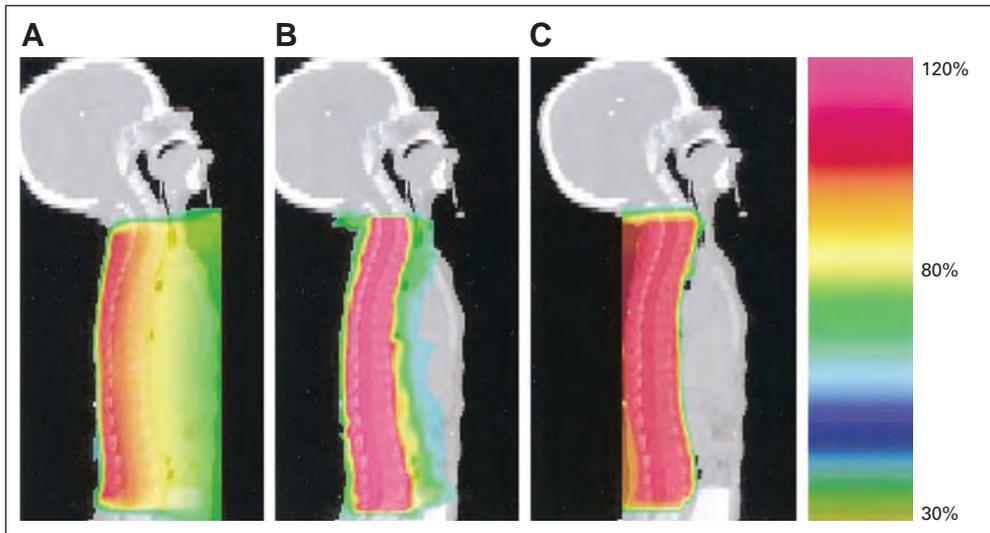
Isodose distribution in the sagittal projection along the spinal column for (A) x-rays, (B) intensity-modulated radiation therapy, and (C) protons.
